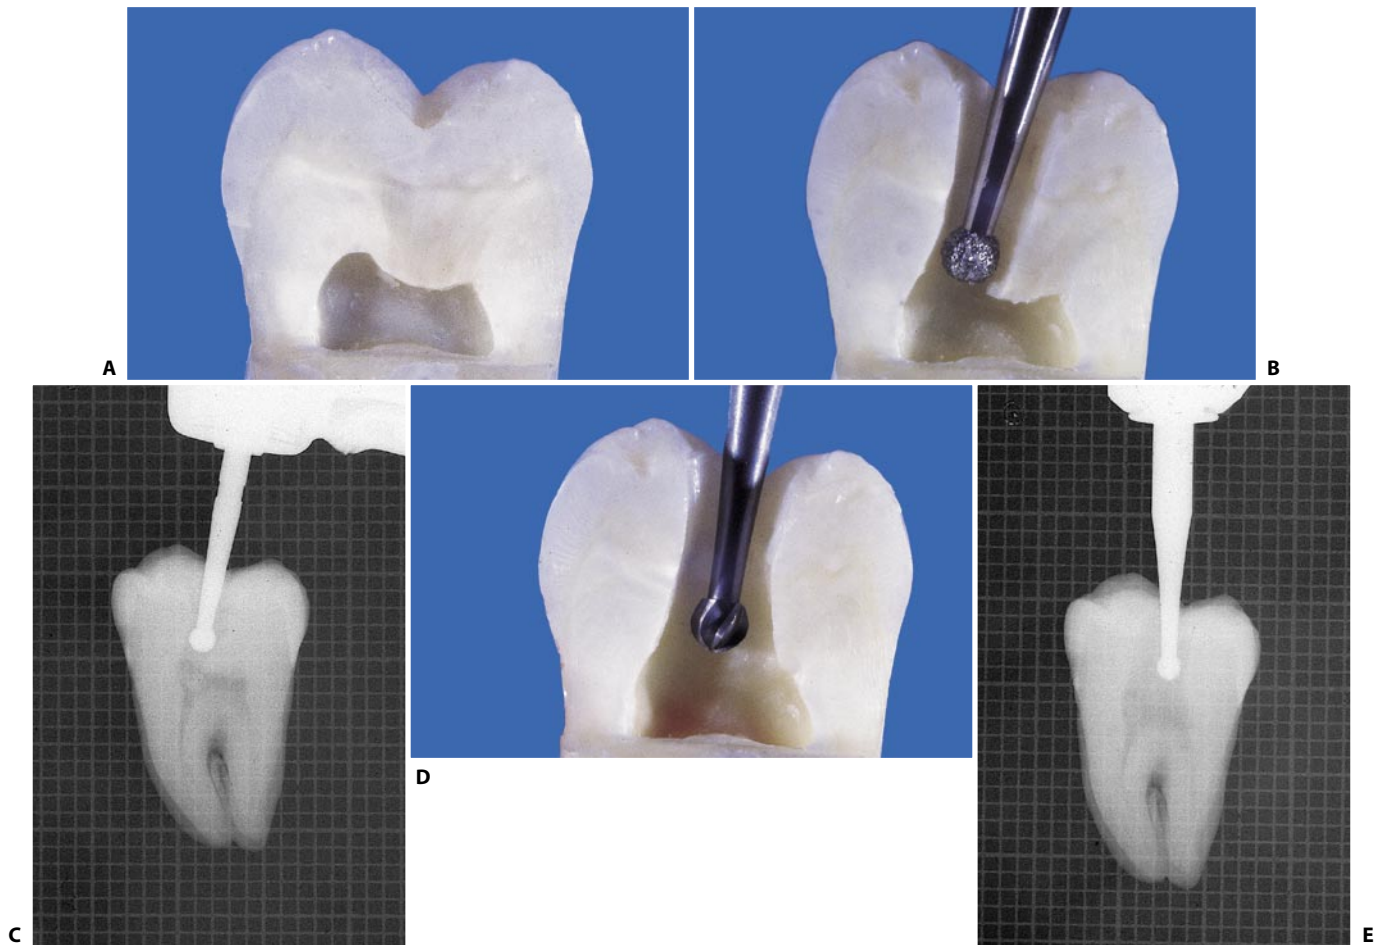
A. Pulp chamber in a mesiodistal section. B. The round diamond bur penetrates toward the widest pulp horn. C. Radiographic appearance of the penetration phase. D. The low-speed round bur removes the residue of the chamber roof. E. Radiographic appearance of the widening phase (continued).
